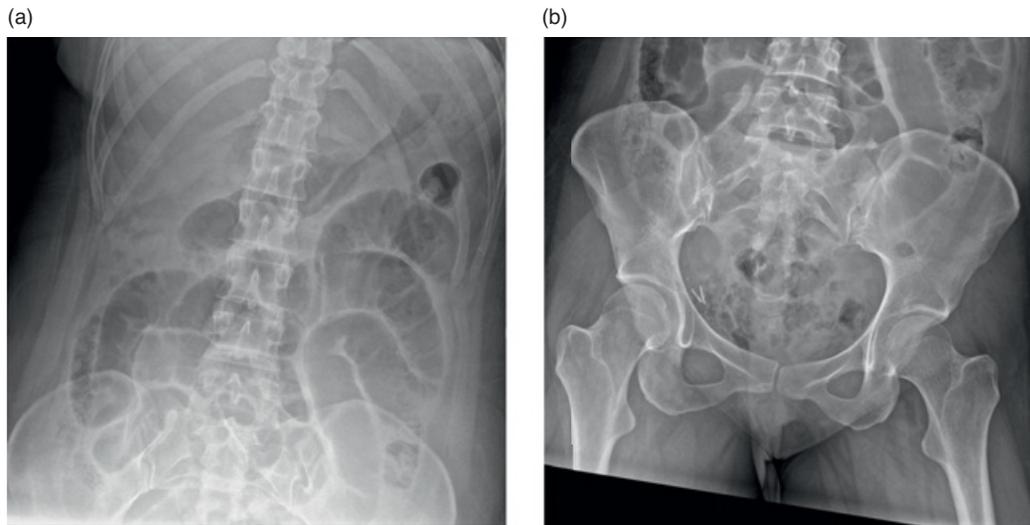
(a) Abdominal radiograph with dilated loops of small bowel. (b) Abdominal radiograph with dilated loops of large intestine and air in colon.
